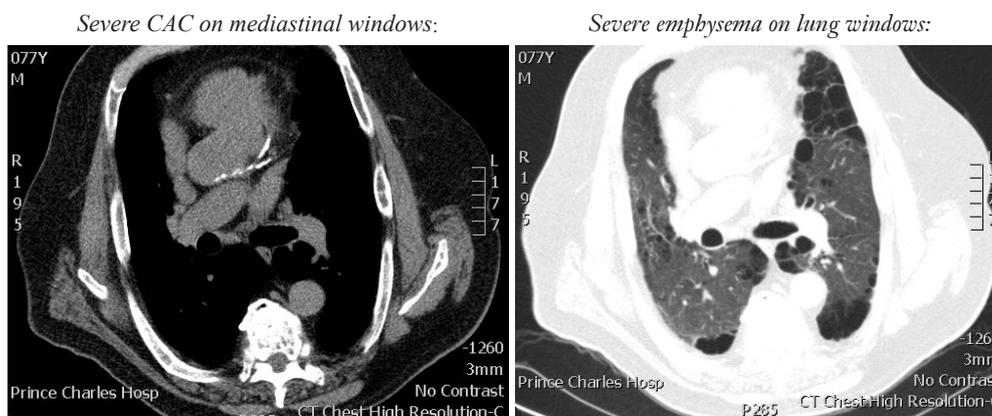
CAC on CT chest scan in a 77-year-old male patient with COPD and emphysema. CAC, coronary artery calcification; CT, computed tomography. Reproduced with permission from (3).
